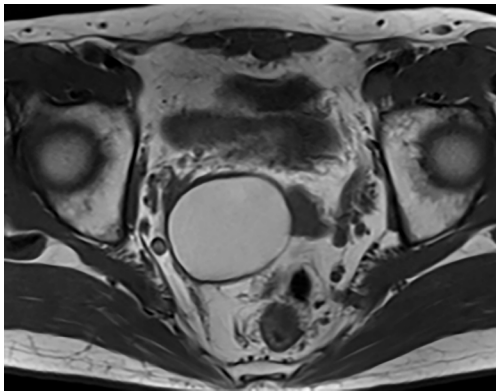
The seminal vesicle cyst showed no tendency to enlarge. Magnetic resonance imaging results at five years after treatment showed that maximum diameter had decreased to approximately 5 cm.
